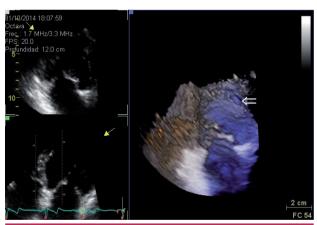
3D echocardiography image showing the crypt opening from the left ventricular septal surface (arrow).
